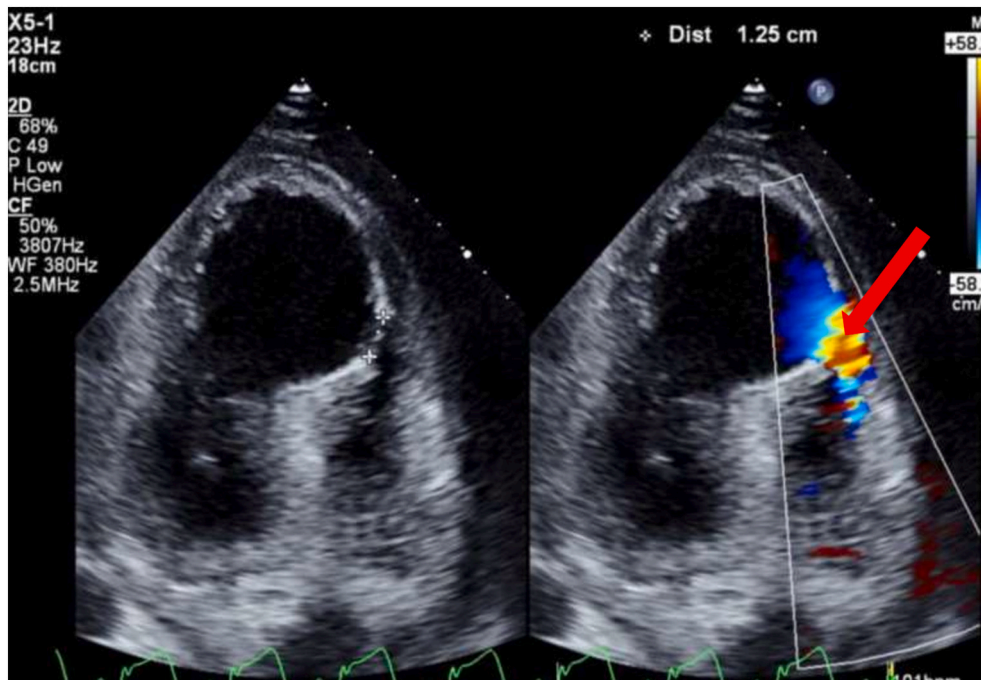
Reverse apical 4-chamber showing muscular VSD (arrow) with color Doppler indicating left-to-right shunt.
